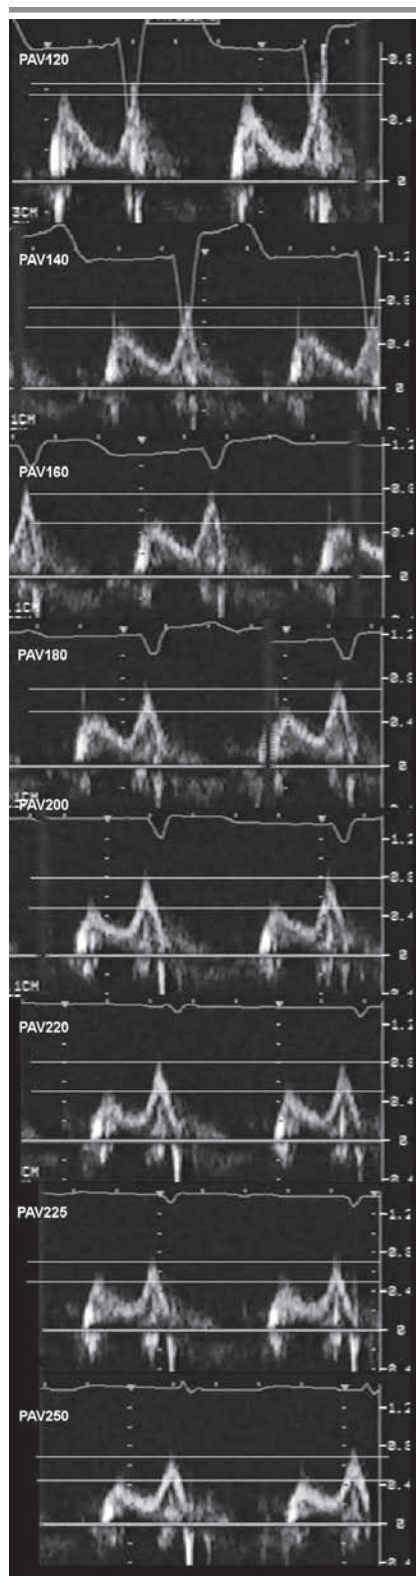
Echocardiographic Doppler transmitral flow pattern for all of the atrioventricular delays tested in study subject number 3
